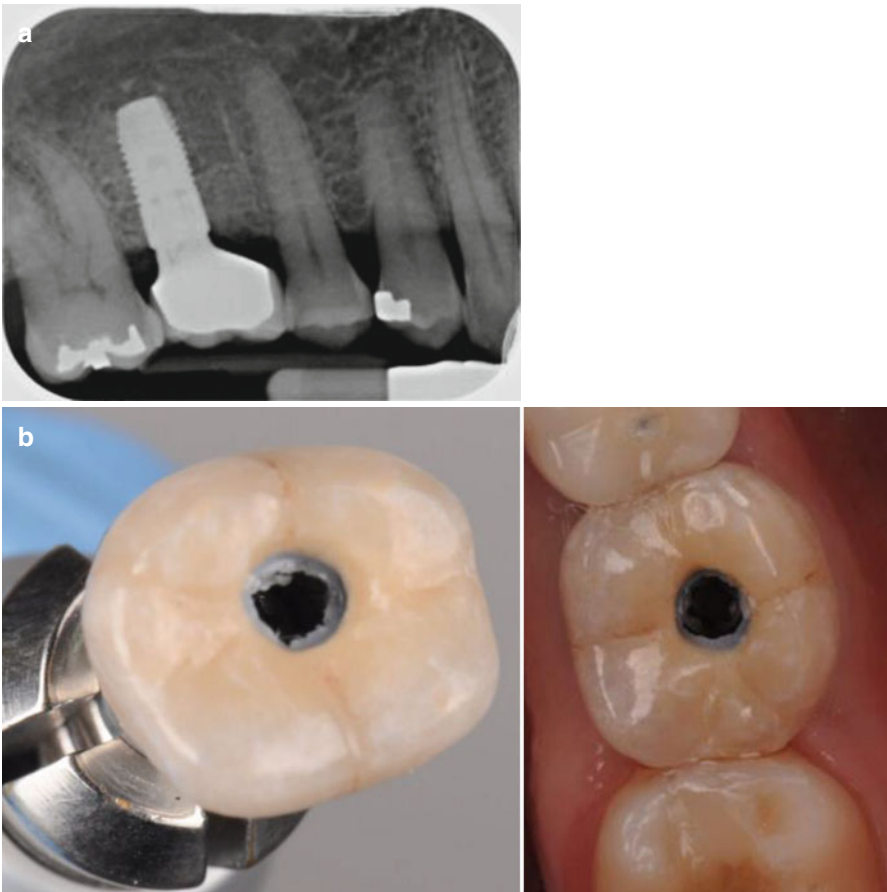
(a) Radiograph of final cemented restoration confirms seating of the restoration and no excess cement present. (b) Screw-retained implant crown decreases the risk of leaving excess cement subgingivally
